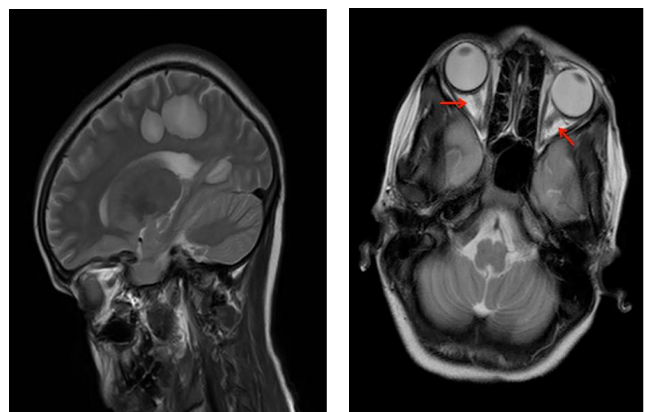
MRI Brain (T2 Saggital image) showing Hyperintense Parieto - Occipito - Basal ganglia lesions; Fig3: MRI Orbit (T2 axial image) showing Bilateral Optic Nerve thickening and hyperintensity.
